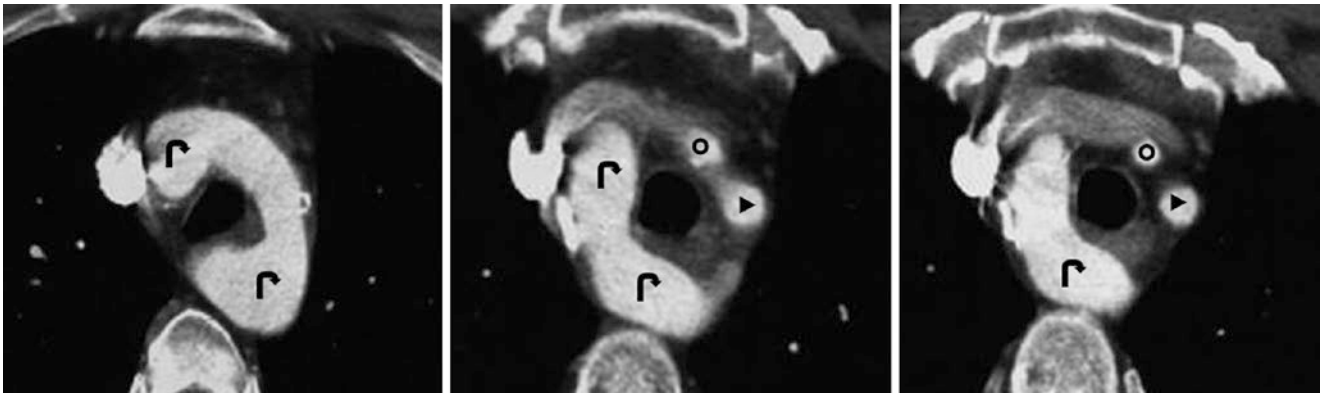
In a 45-year-old patient, a contrast-enhanced CT (caudal to cranial images) demonstrates a double aortic arch (*curved arrows*) that surrounds both the trachea and esophagus. This patient suffered from recurrent aspiration pneumonia, necessitating surgical repair. *Aortic*
